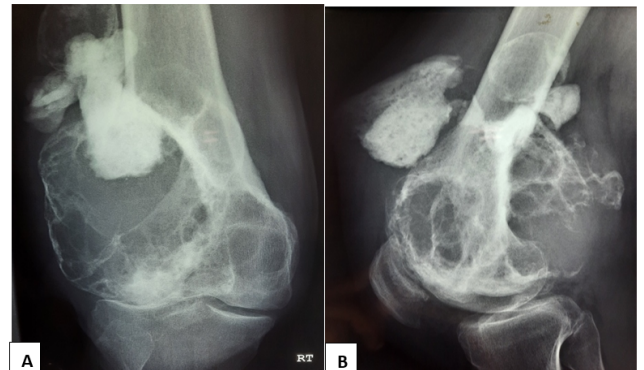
Recurrent GCT; (A): Anteroposterior Radiograph of the right knee shows an expansile lytic lesion of the lateral femoral condyle that extends into subchondral bone, destruction of the lateral cortex and an associated soft tissue mass; (B): Lateral Radiograph of the right knee shows the extension of lesion into the soft tissues
